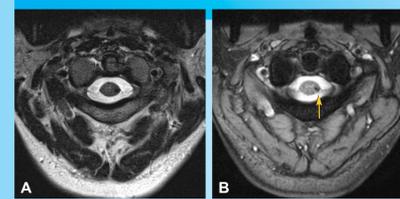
MRI cervical spine of 41 year old. The small CM in the left side of the spinal cord is very subtle on axial TSE T2 (A) and much more conspicuous on 2D MEDIC (B, arrow).
